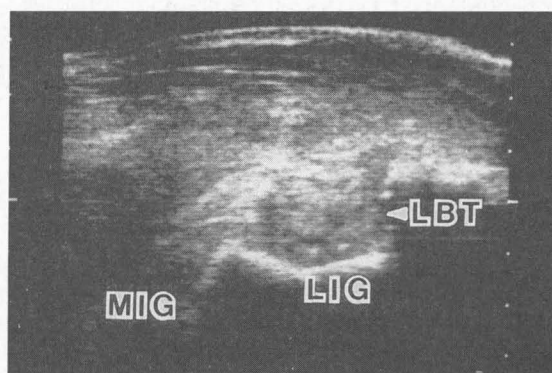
Ultrasonogram (transverse scan) of the right bicipital tendon. Notice multiple small hypoechoic areas in the lateral portion of the tendon. MIG = medial intertubercular groove; LIG = lateral intertubercular groove; LBT = lateral portion of the biceps tendon.
